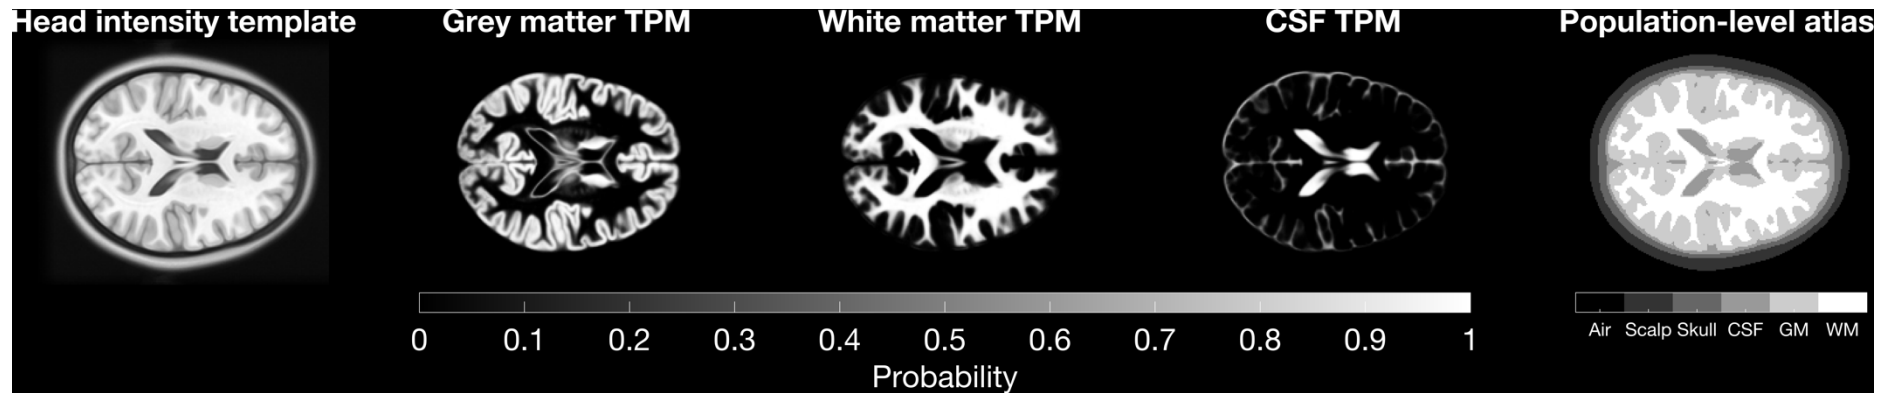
Example adult structural MRI data to produce the MNI152 population-level atlas, produced using T_1 -weighted MRI data. Far left: T_1 -weighted head intensity template. Centre right: grey matter tissue probability map (TPM). Middle: white matter tissue probability map. Centre right: CSF tissue probability map. Far right: population-level atlas mapping the spatial distribution of grey matter, white matter, CSF, skull and scalp (see colourbar). Data for figure taken from Fonov et al. (2009) and <https://www.ucl.ac.uk/medphys/research/borl/resources/>. Copyright (C) 1993–2004 Louis Collins, McConnell Brain Imaging Centre, Montreal Neurological Institute, McGill University.
